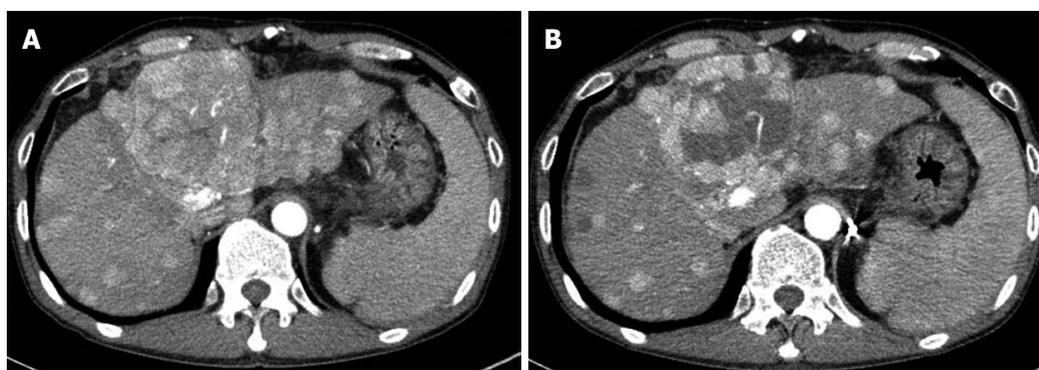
Favorable response of patient with multinodular hepatocellular carcinoma treated by hepatic artery infusion chemotherapy. A: Patient with multinodular type hepatocellular carcinoma (HCC) with portal vein thrombosis in baseline liver dynamic computed tomography (CT); B: After hepatic artery infusion chemotherapy, this patient showed partial necrosis of HCC in a follow-up liver dynamic CT.
